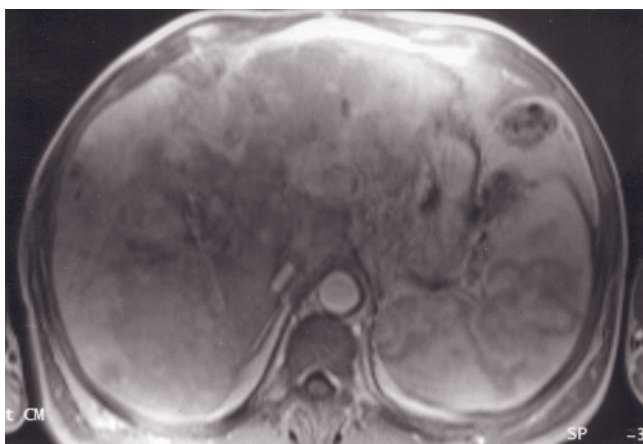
Focal HCC with bile duct obstruction. Coronal T2-weighted SS-ETSE (a) and immediate postgadolinium SGE (b) images. There is a large lesion in the left hepatic lobe that demonstrates minimally hyperintense signal on T2-weighted images (a) and moderate heterogeneous enhancement immediately after gadolinium administration (b), consistent with a large HCC. Note that the mass causes ductal obstruction (arrows, a) of the biliary tree in segment 2 of the left lobe.
